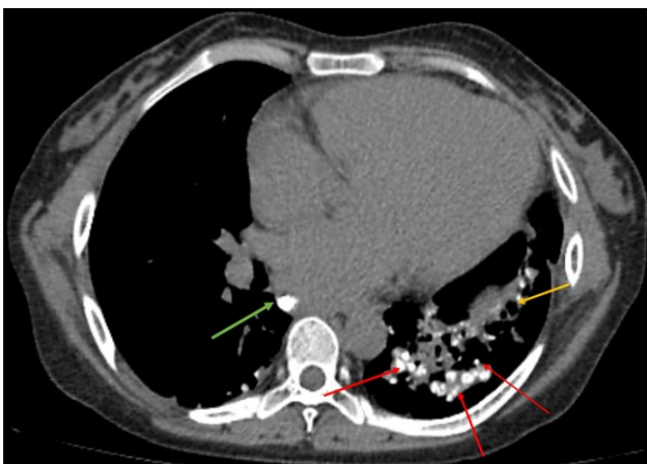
Computed tomography in the axial in the mediastinum/soft tissue window. The image show multiple solid nodules with well-defined margins presenting large calcifications (red arrows) and bronchiectasis (yellow arrow). In the mediastinum, calcified lymph nodes are also shown (green arrow)
